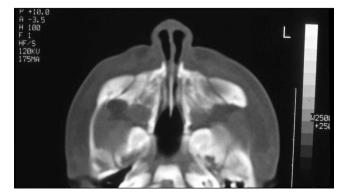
CT of piriform aperture stenosis.
